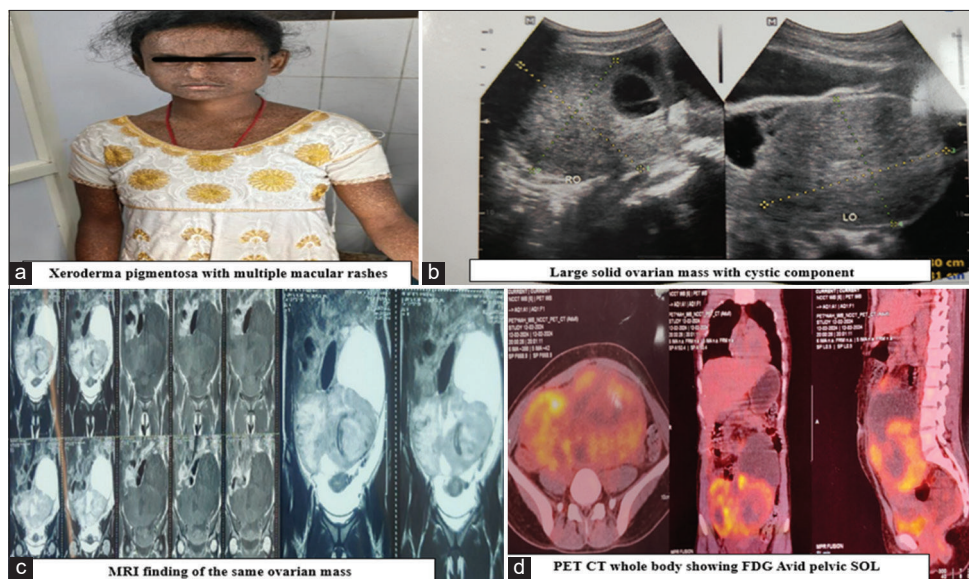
Clinical and radiological presentation. (a): Phenotypic appearance of xeroderma pigmentosum; (b): Ultrasound of pelvic mass; (c): Magnetic resonance imaging pelvis showing solid-cystic mass; (d): Positron emission tomography-computed tomography showing fluorodeoxyglucose-avid lesion
